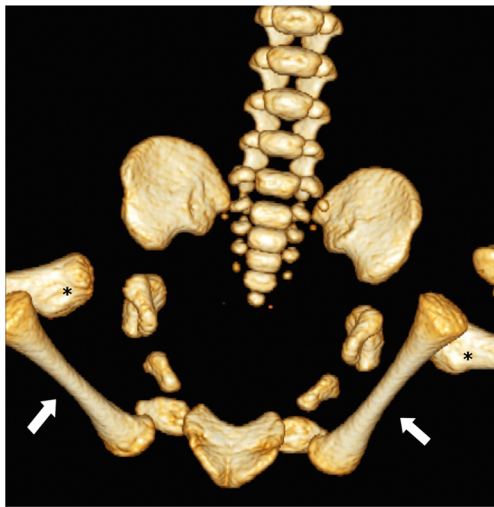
Volume-rendered CT image of the neonatal ischiopagus parasiticus tetrapus. *White arrows* show cranially oriented, hypoplastic additional legs articulating with an inverted, rudimentary and anteriorly fused additional pelvis. The normally oriented legs are marked with *asterisks*
